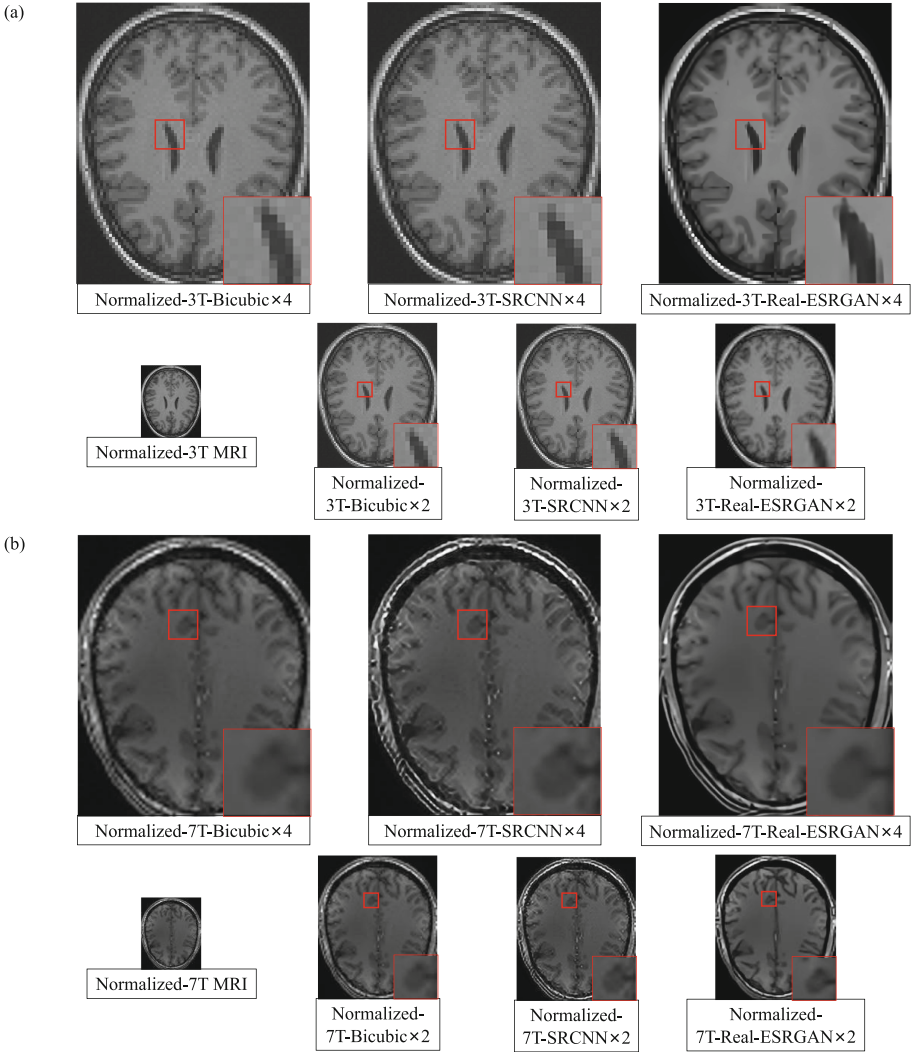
The reconstructed MRI results based on the proposed SR-MRI framework. (a) shows the reconstructed results based on the normalized-3T MR neuroimages; (b) shows the reconstructed results based on the normalized-7T MR neuroimages. ($\times 2$ is the two times magnification for super-resolution reconstructed images, and $\times 4$ is the four times magnification.)
